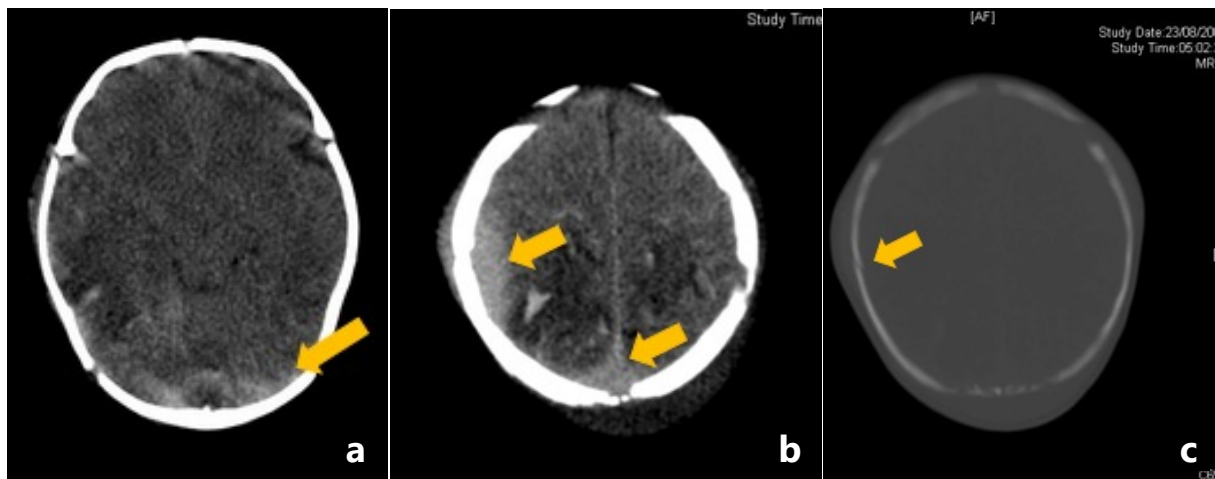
Non-enhanced CT brain of a full-term infant born by caesarean delivery who presented with seizure and apnoea. (a) There is evidence of subdural haematoma along the tentorium, (b) epidural haematoma, and (c) a right parietal skull fracture.
